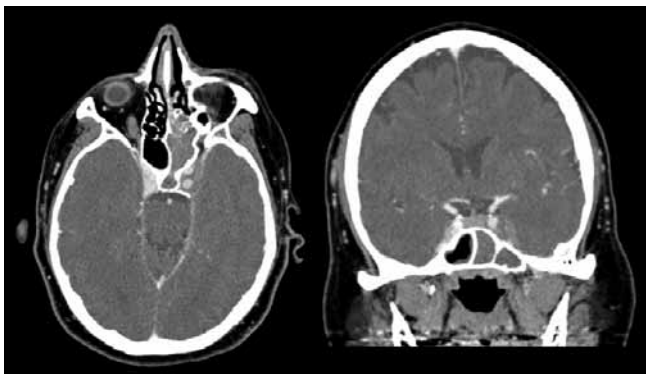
Contrast enhanced CT showing complete opacification of the left sphenoid sinus and non-opacification of the left cavernous sinus, suggesting thrombosis.
